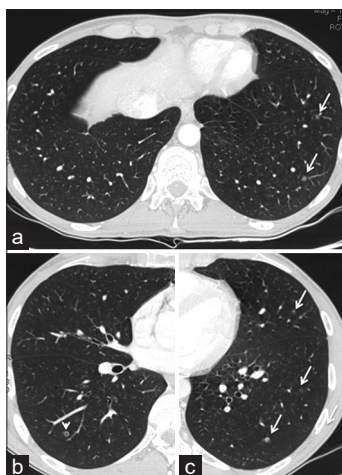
(a-c) HRCT examinations show a combination of micro-nodules (arrows) and thin-walled cysts (arrowhead), around or adjacent to bronchi
